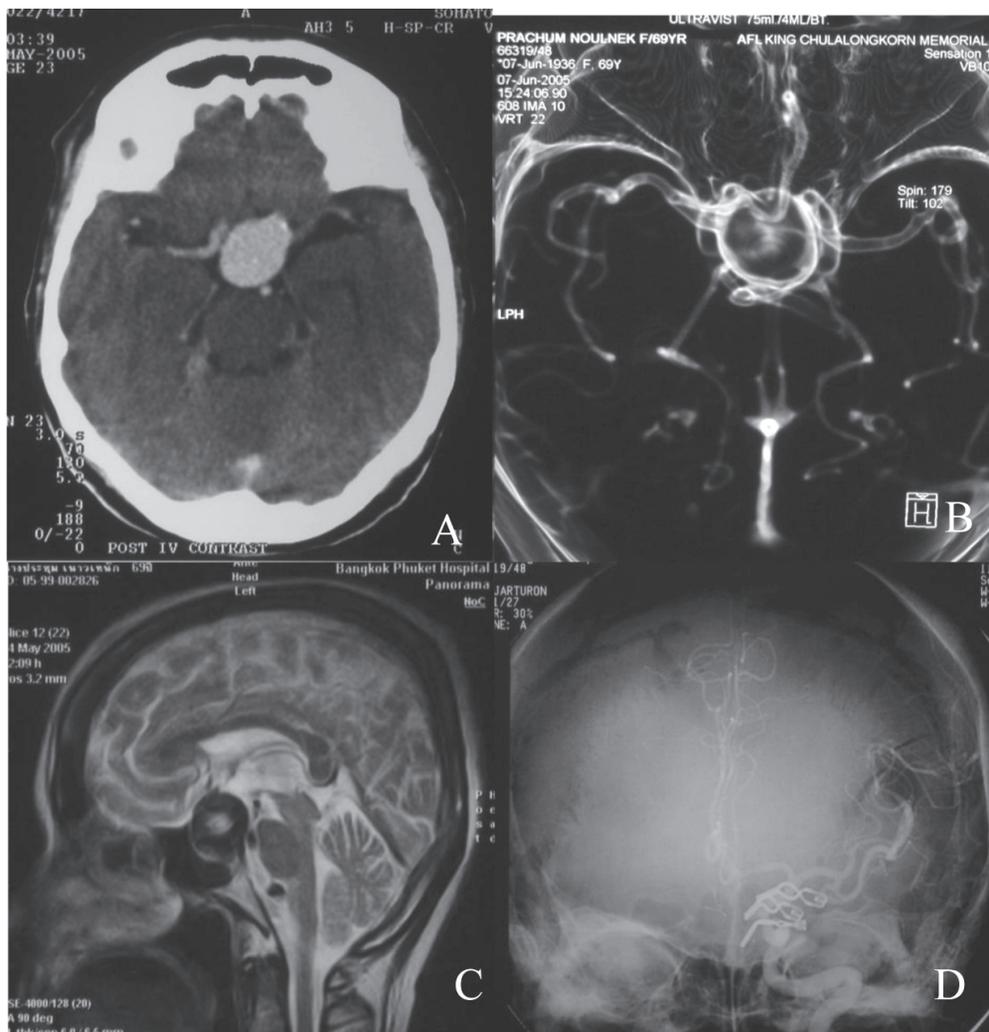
A 69-year-old female (case NO.2) presented with visual field defect. A contrast CT scan (A) revealed a vivid contrast enhancing mass at suprasellar region. CTA and MRI revealed a giant saccular supraclinoid Lt. ICA aneurysm (B,C). Clip reconstruction was performed with suction decompression technique. Post-operative DSA (D) showed a well obliterated aneurysm and patent Lt. ICA. Lt. frontal lobe hematoma was occurred at postoperative period, which required hematoma removal. Vision gradually improved at 1.83 year-follow up.
